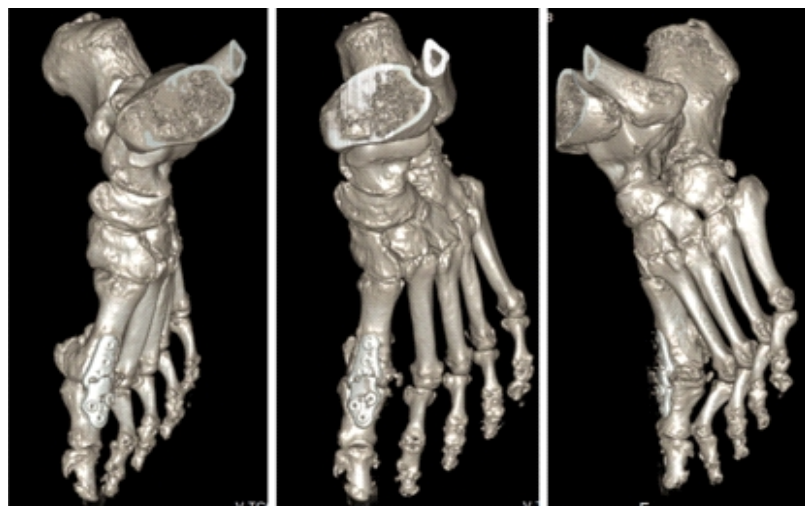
Failure of primary arthrodesis. Computed tomography – 3D reconstruction demonstrating established pseudarthrosis with plate breakage.
